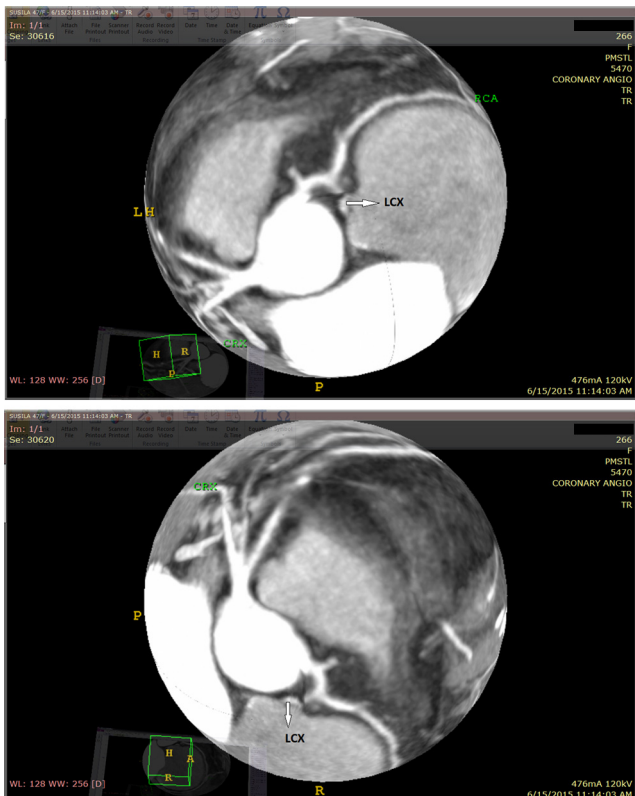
CT angiography showing origin of LCX from RCA.
